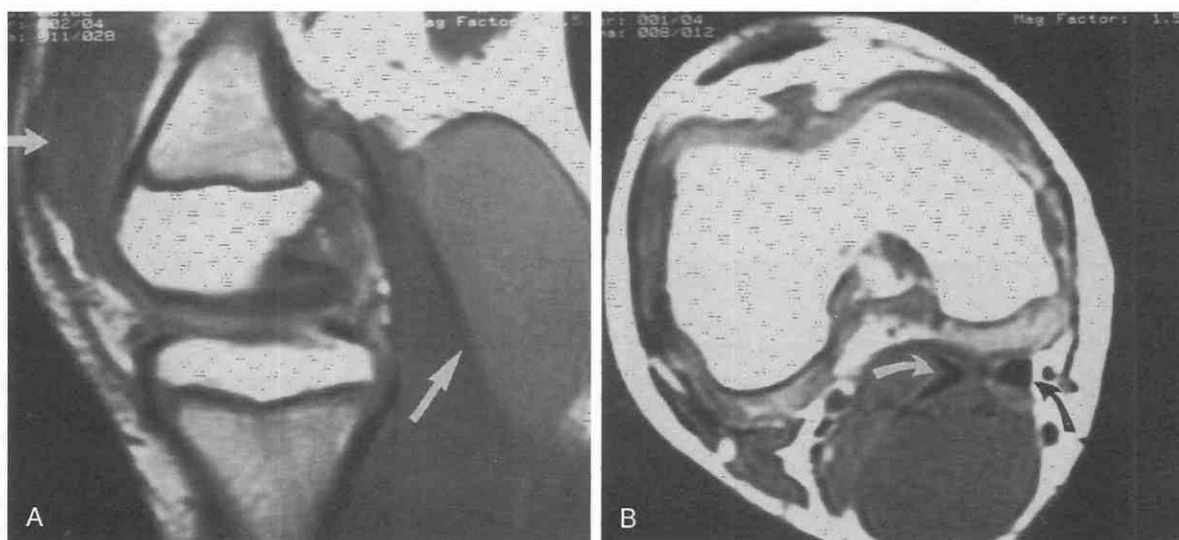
Popliteal cyst. Sagittal and coronal T1-weighted images show fluid in the knee joint and popliteal cyst, the latter representing a distended, communicating semimembranosus-medial gastrocnemius bursa. A, The sagittal image shows low-signal-intensity fluid at the "cyst" and suprapatellar bursa (*small arrow*). Normal high-signal-intensity fatty marrow is seen at the epiphyses. B, The axial images show the fluid-filled bursa and its relationship to the semimembranosus tendon (*curved black arrow*) and the medial gastrocnemius tendon (*curved white arrow*).
